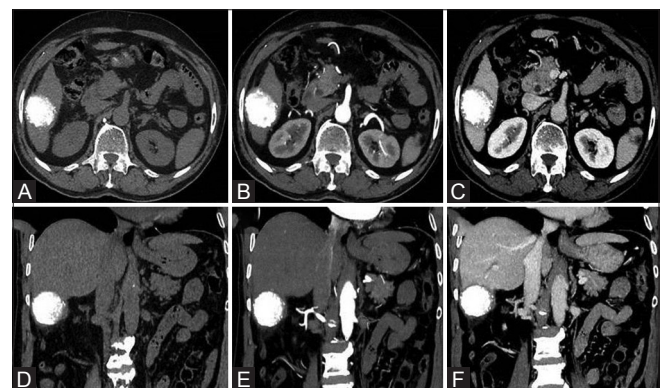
(A–F): Follow up at 12 months. Axial and coronal computed tomography in unenhanced (A and D), arterial (B and E), and portal venous phase (C and F) showing uniform lipiodol deposition in the tumor without any arterially enhancing component suggestive of complete response. Also noted is resolution of peritumoral fluid
